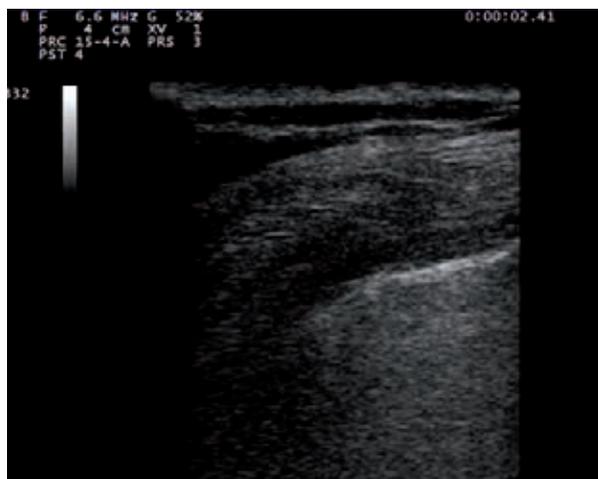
Ultrasonography at admission.
